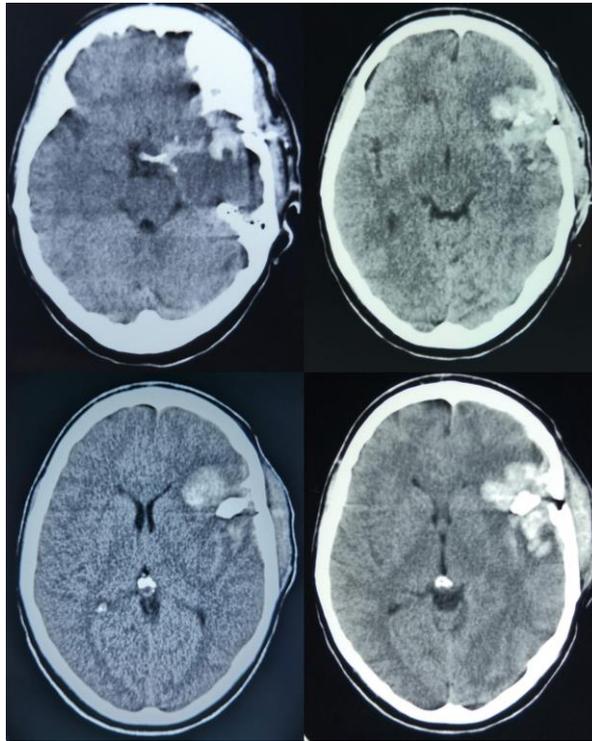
Initial non-contrast CT brain shows acute haemorrhage in the dorsolateral frontal lobe, a corresponding bone defect and significant extra-axial oedema. The path of the iron bar looks to pass medially and rostrally following penetration of the skull.
